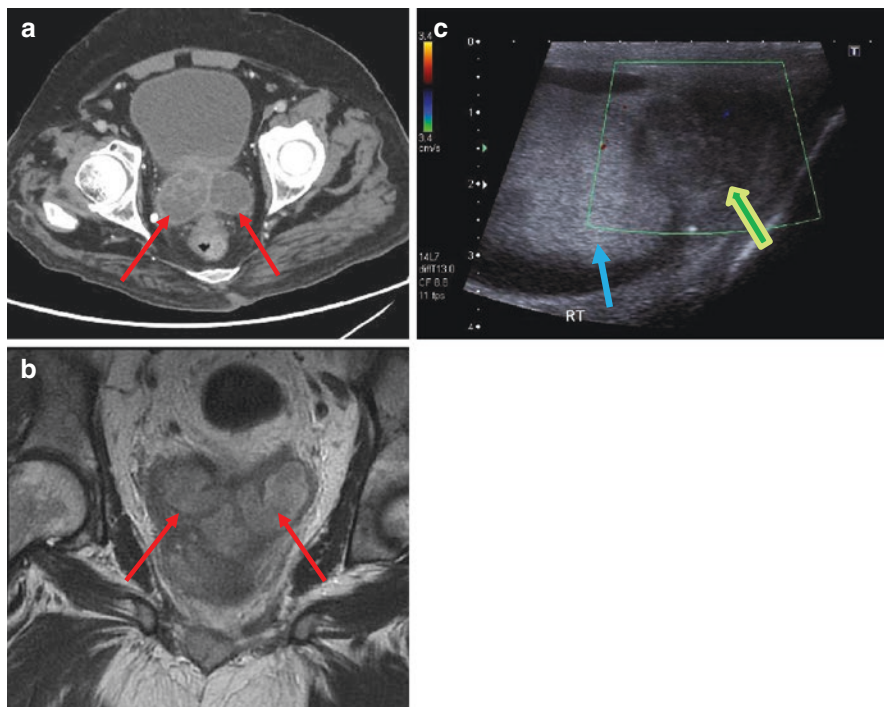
Epididymal and seminal vesicle tuberculosis: (a) Axial contrast enhanced CT through base of bladder shows grossly distended seminal vesicles (red arrows). (b) Coronal T2 weighted MRI sequence also demonstrates gross dilatation of the seminal vesicles. (c) Ultrasound testis (blue arrow) with a swollen inflamed epididymis at the lower pole of the testis (green arrow) on Image c. *Image courtesy Dr Uday Patel, Consultant Radiologist, St George's Hospital NHS Trust, London, UK*
